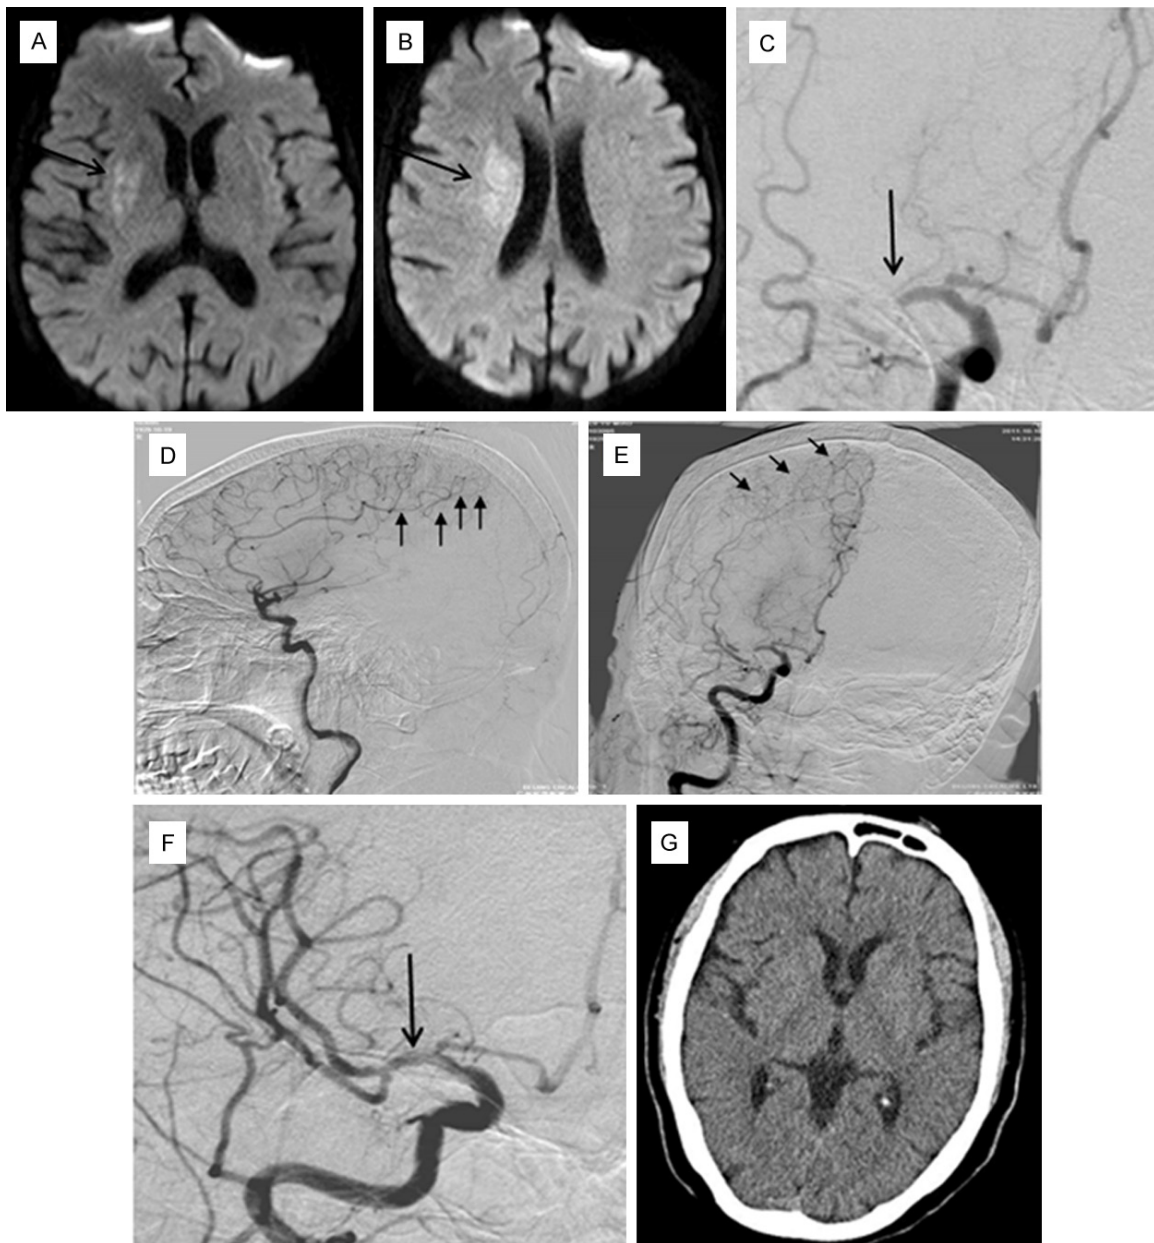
Radiographic and angiographic images of Case 1. (A) DWI showed a fresh infarction in the right basal ganglia area (black arrow). (B) DWI showed a fresh infarction in the right corona radiata (black arrow). MR brain DWI image before thrombolysis. (C) M1 segment of the right MCA was subtotally occluded (black arrow). Lateral (D) and anterior (E) cerebral angiographic images showed compensatory leptomeningeal arteries from anterior cerebral artery (black arrows). (F) The occluded MCA was recanalized (black arrow). (G) Postoperative CT showed no hemorrhagic transformation.
